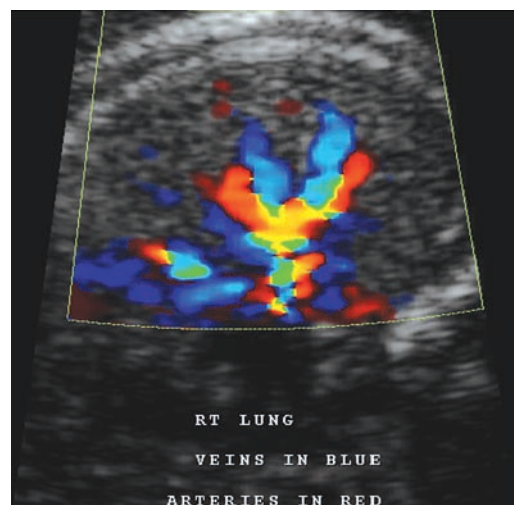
Color Doppler image of pulmonary vascularity.
